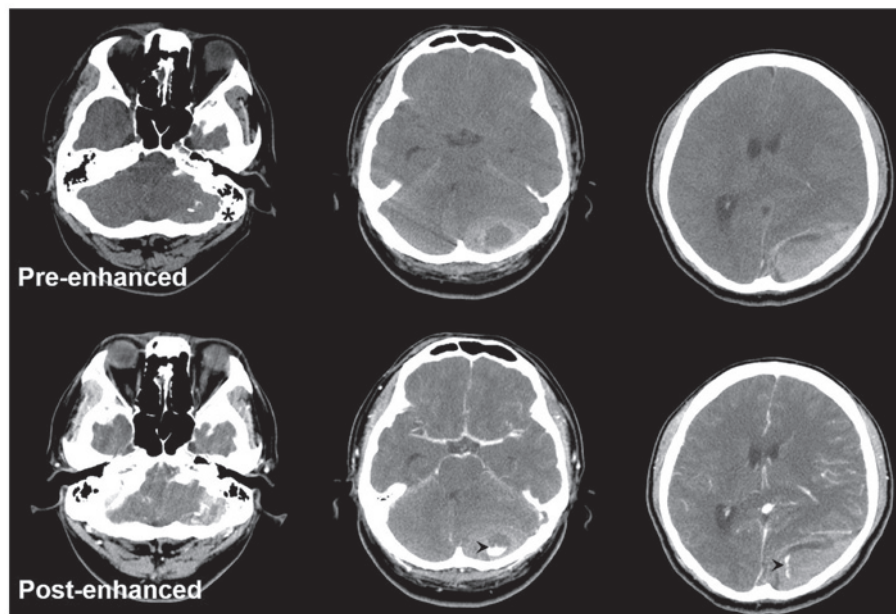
Preoperative computed tomography scan demonstrating a huge and mixed-density epidural hematoma on the left parieto-occipital region, with a severe mass effect. Note the osteolytic change on the occipital and petrous bone (asterisk) and the enhanced portion (arrow head) in the hematoma.
